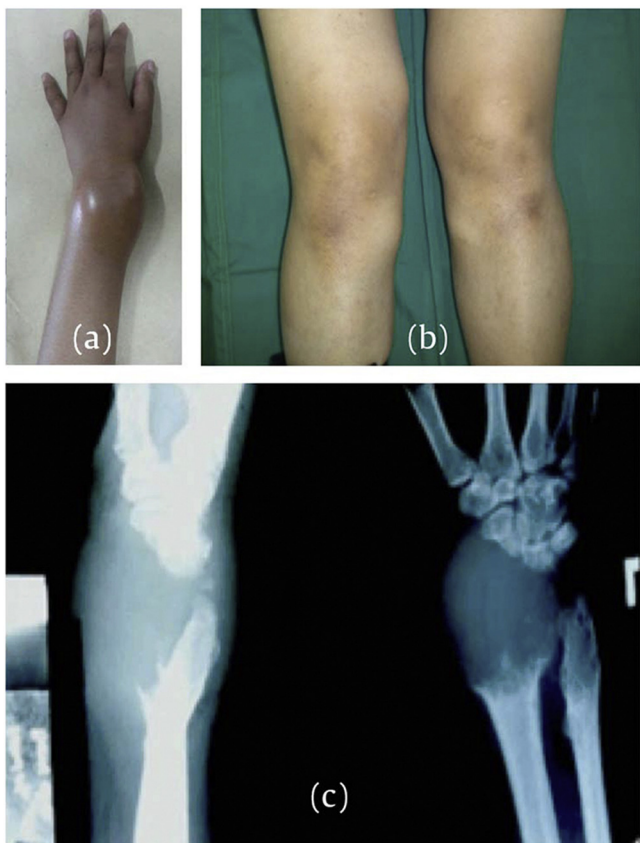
Clinical and X-ray Findings.
